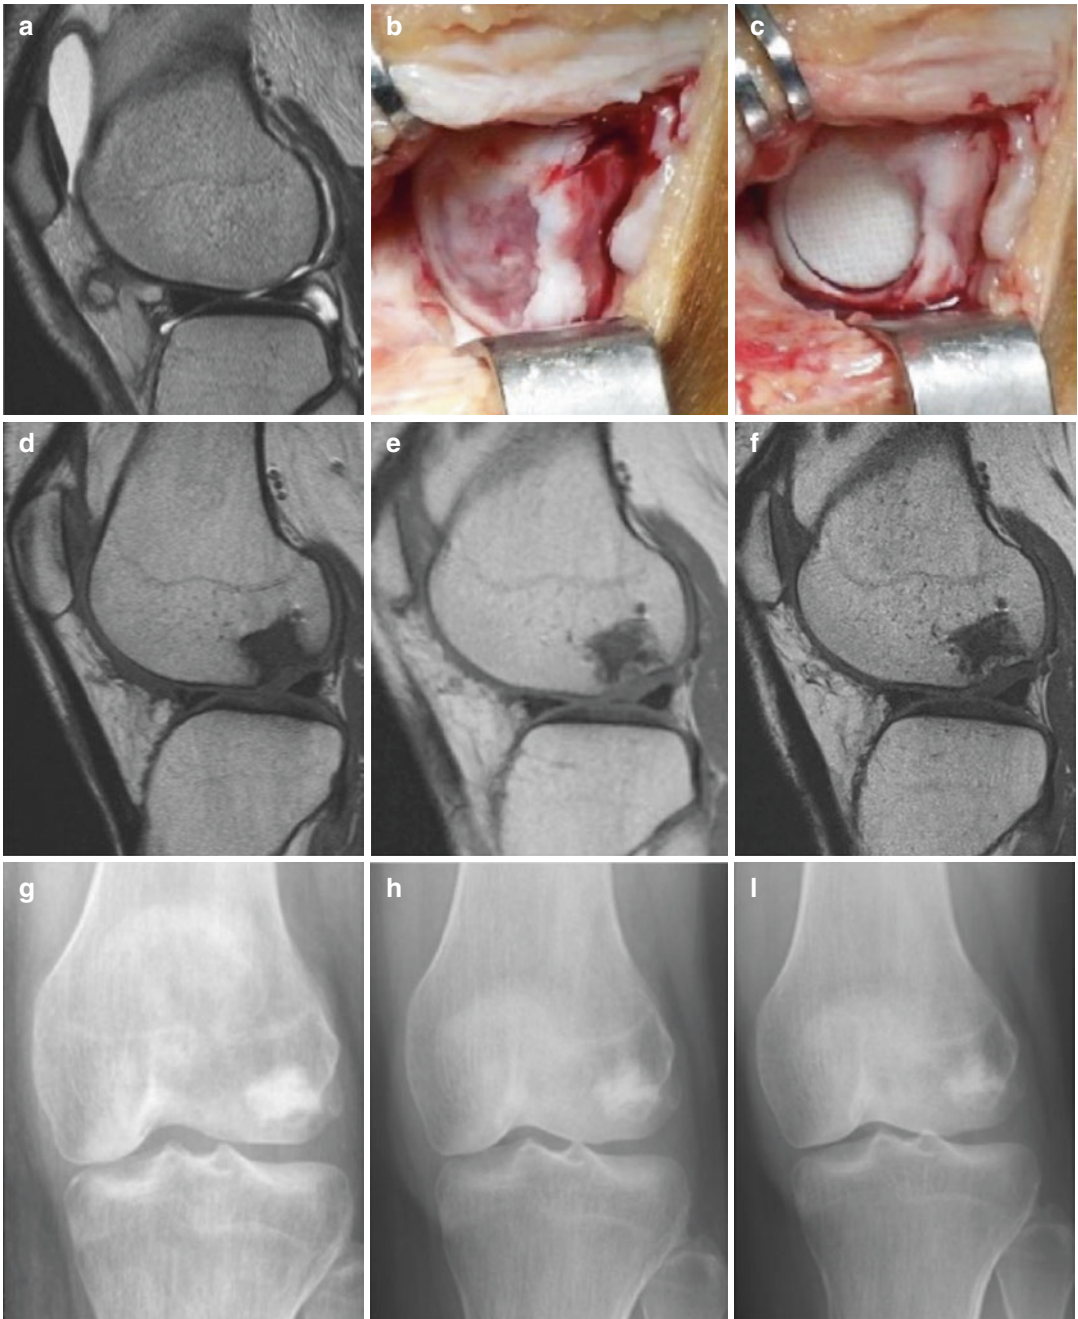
A 32 year-old female with mild OA and an osteochondral defect on her LFC. Patient treated with a single aragonite-based implant. (a) Baseline MRI; (b) intraoperative view on the defect; (c) Agili-C implantation; (d) 6 months' MRI; (e) 12 months' MRI; (f) 24 months' MRI; (g) 6 months' X-ray; (h) 12 months' X-ray; (i) 24 months' X-ray. (Reproduced with permission from Â© Cartiheal, Inc. All rights reserved)
